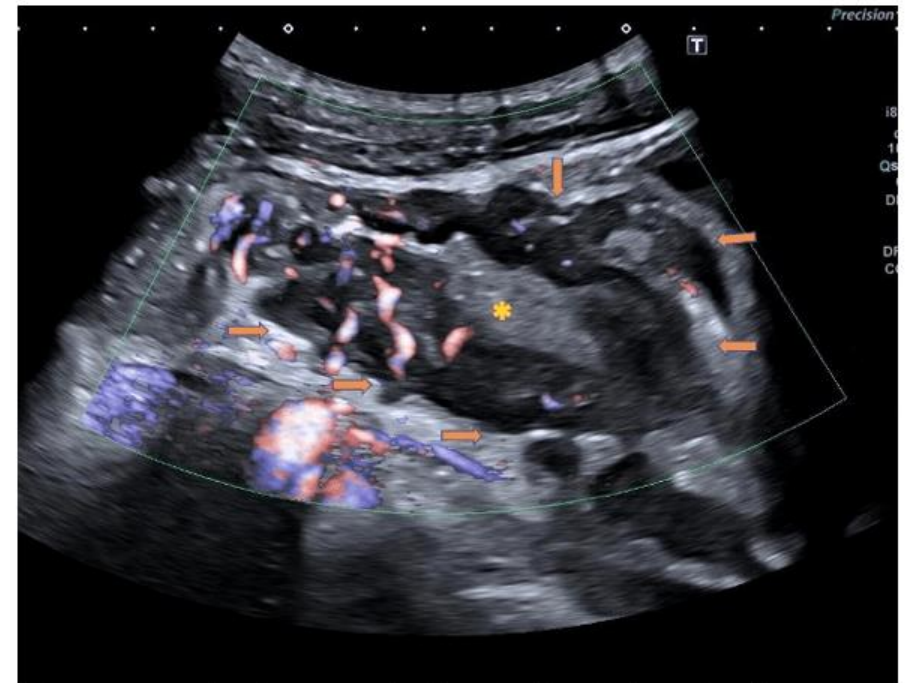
Increased Colour Doppler flow in the thickened wall.
